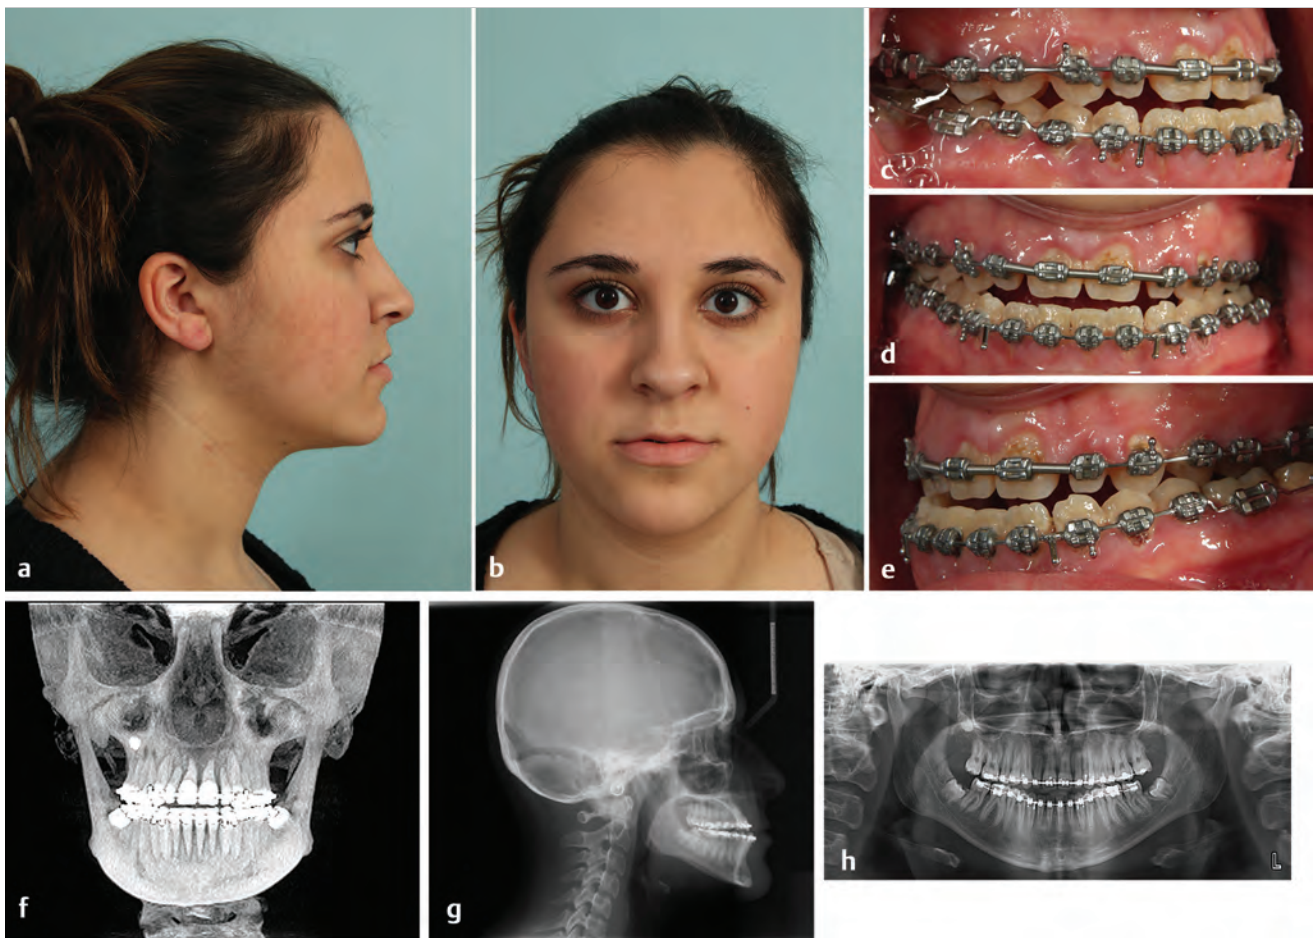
A 20-year-old woman with a class III skeletal pattern and a lower facial asymmetry. (a,b) Preoperative photographs demonstrating a thin and poorly supported upper lip. (c–e) Preoperative dental occlusion. (f–h) Preoperative radiographs showing maxillary sagittal hypoplasia and mandibular asymmetry.
